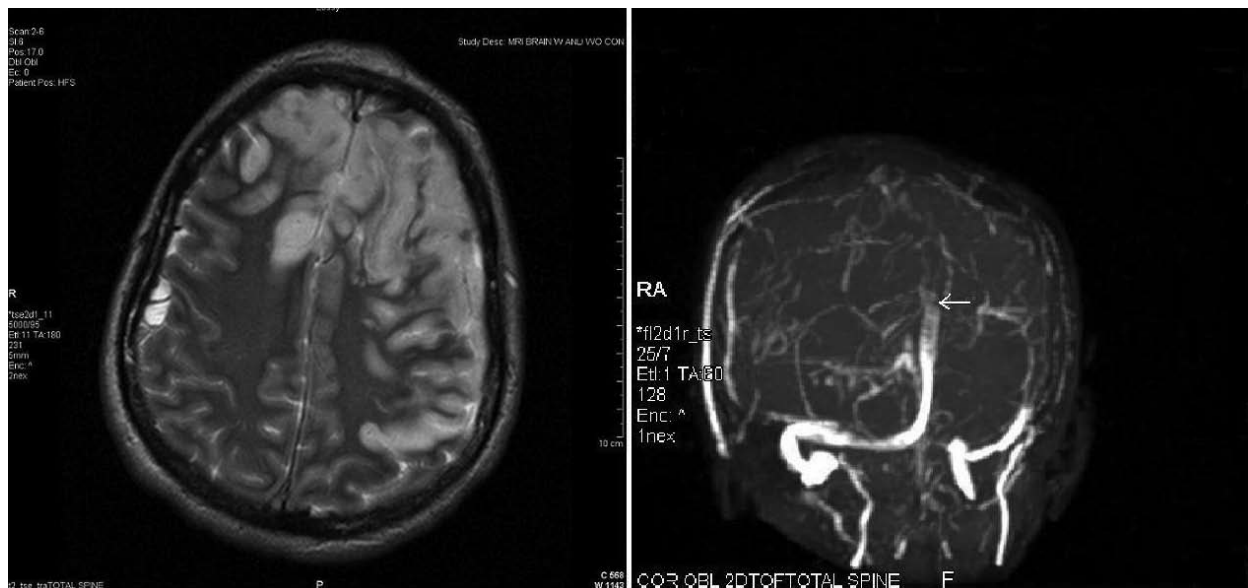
Magnetic resonance imaging reveals extensive venous infarcts involving the frontal and left parietotemporal lobes (left). Magnetic resonance venogram demonstrates extensive thrombosis of the anterior half of the superior sagittal sinus (right).
